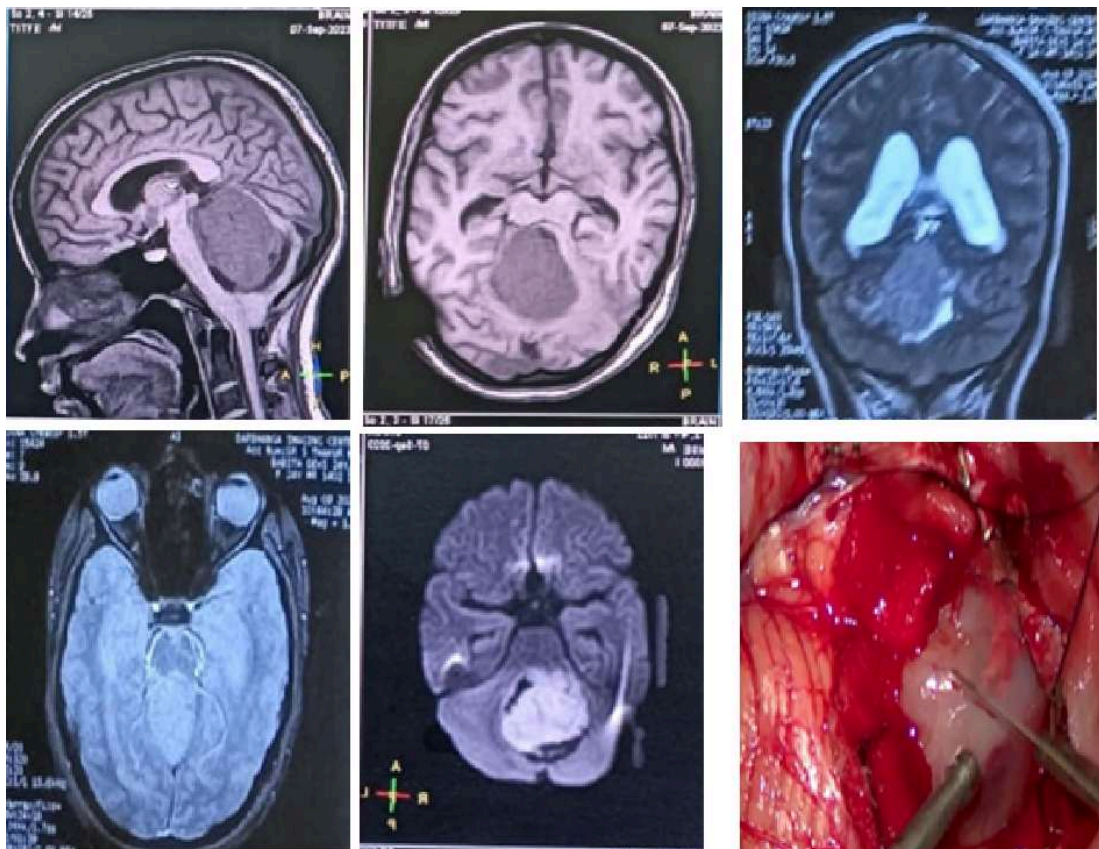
MRI images Showing medulloblastoma and Intra-op images
